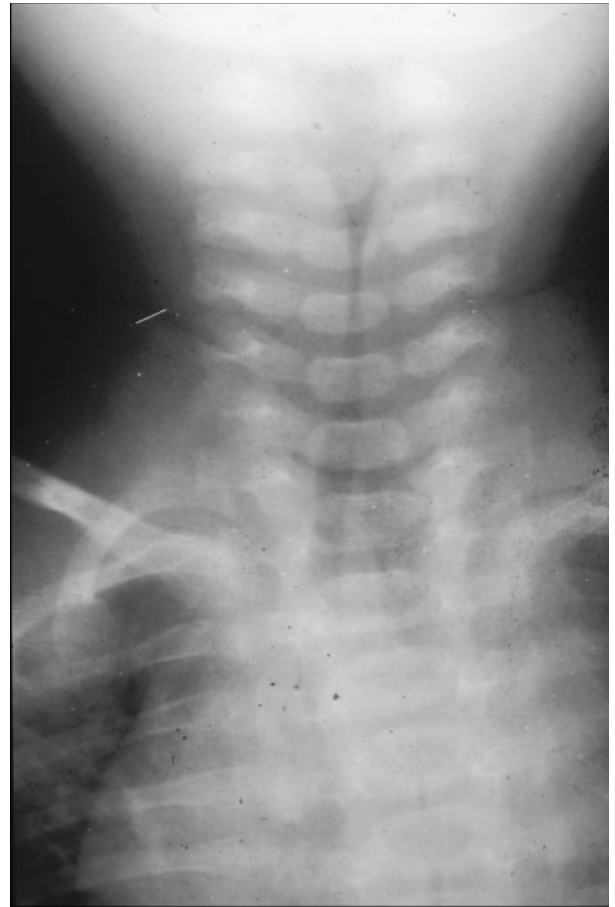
Tapered subglottic narrowing of the airway on radiography, demonstrating the classic "steeple sign" in croup. (Courtesy of Dr Jack Levenbrown, Manhasset, NY.)
